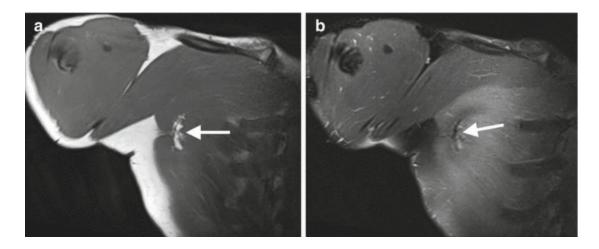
A 37-year-old-man with chronic pain during weight lifting. Coronal T1-weighted MRI (a) shows focal tendon discontinuity and proximal retraction suggestive of a chronic partial tear of the musculotendinous junction (*arrow*). Coronal fat-suppressed T2-weighted MRI shows fibroscar alterations of the retracted tendon (*arrow*, b)
